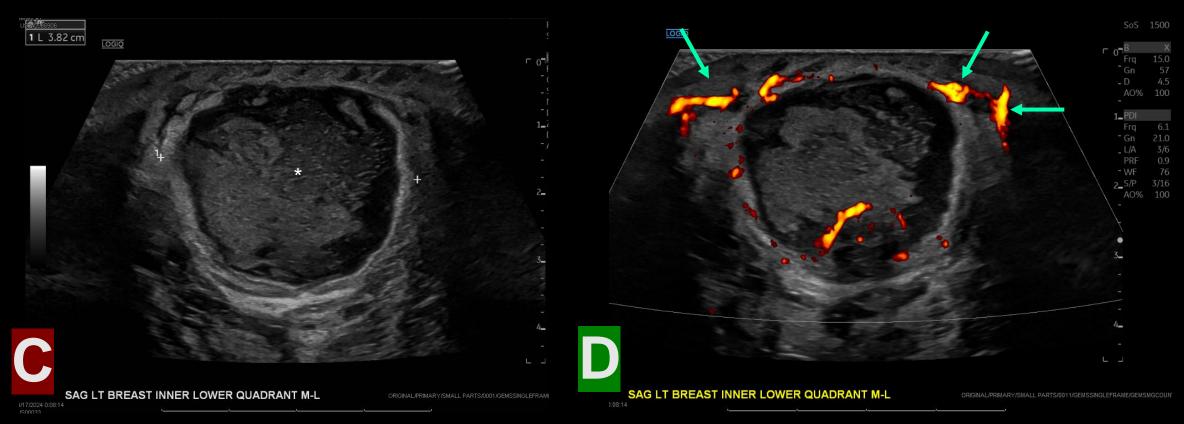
Figure C Thick-walled fluid collection again demonstrating heterogenous internal echogenic texture (asterisk). Figure D Color Doppler demonstrates surrounding hyperemia (green arrows).
